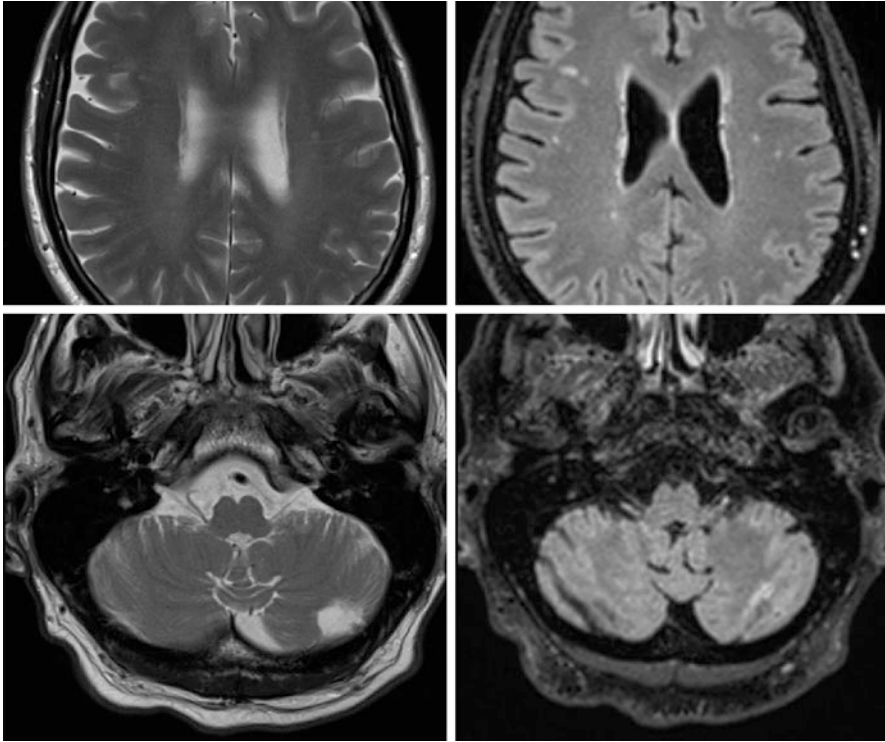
T_2 -weighted TSE (left column) and FLAIR (right column) brain imaging. First row: subcortical white matter hyperintensities better visible on FLAIR compared to T_2 . Second row: cerebellar infarct visible on T_2 TSE which can be missed on FLAIR
